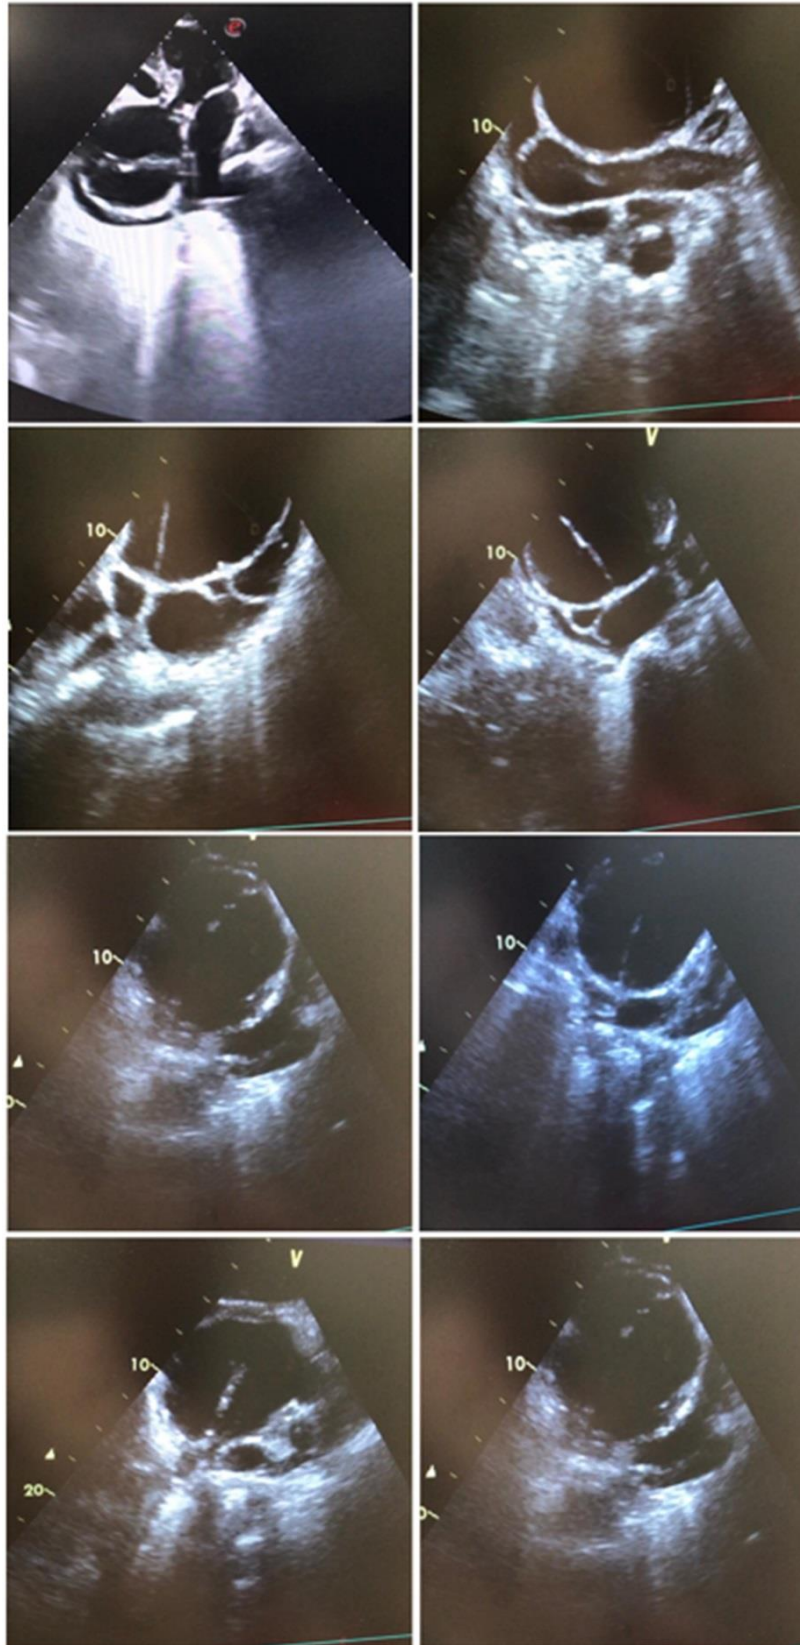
A transthoracic echocardiogram with multiple standard views reveals a large aortic root aneurysm and severe left ventricular enlargement.
